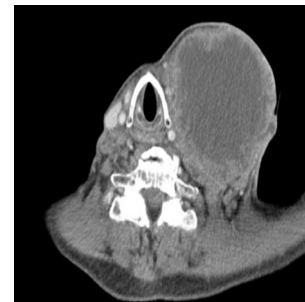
Axial view of CT scan showing fungating neck mass.
